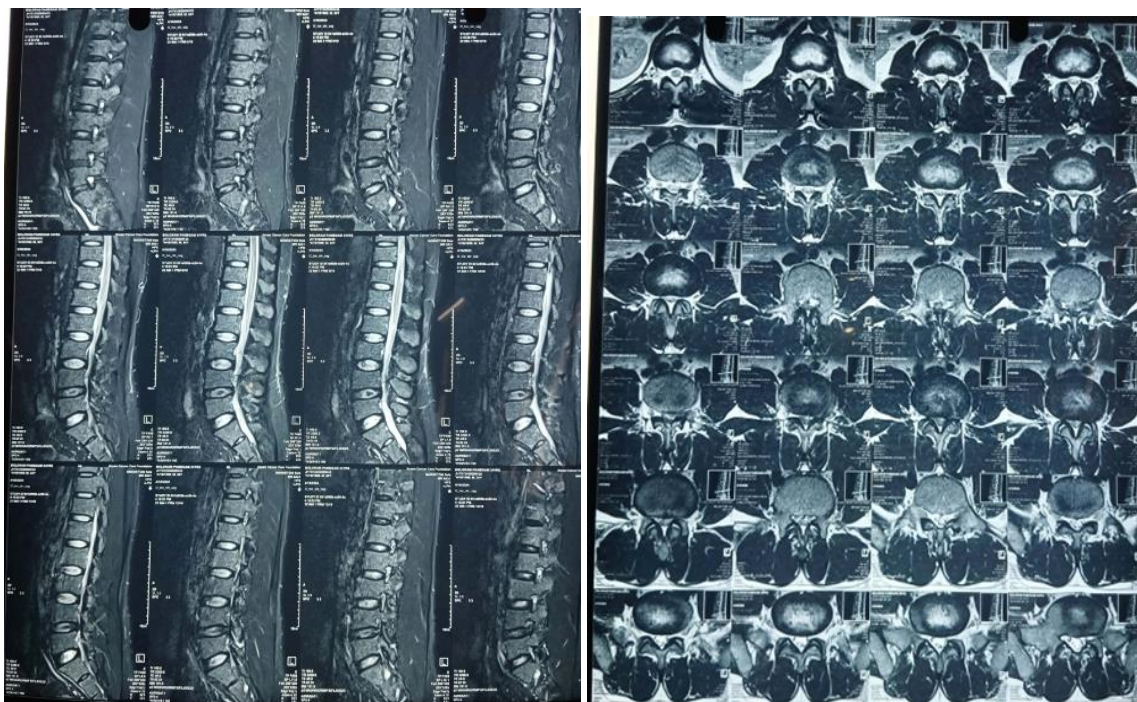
MRI of lumbo-sacral spine (pre surgery).
